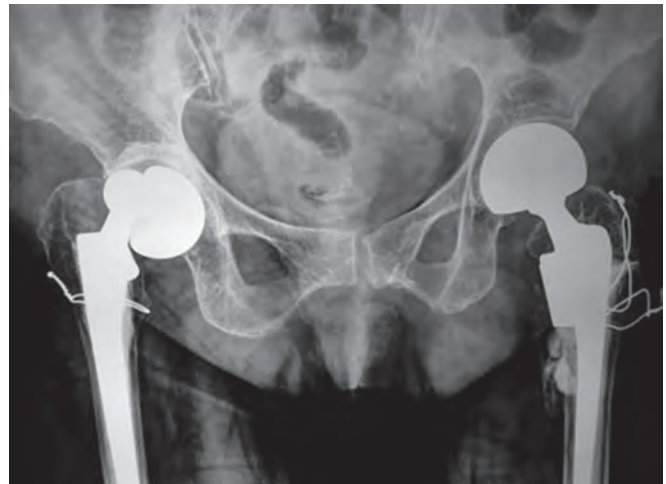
X-ray at presentation
